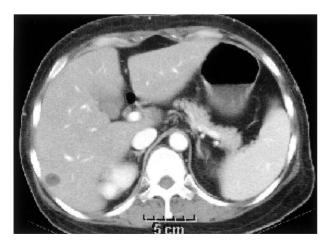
Abdominal-pelvic CT showing small cysts in the liver. No grossly visible mass or lymphadenopathy was present.
